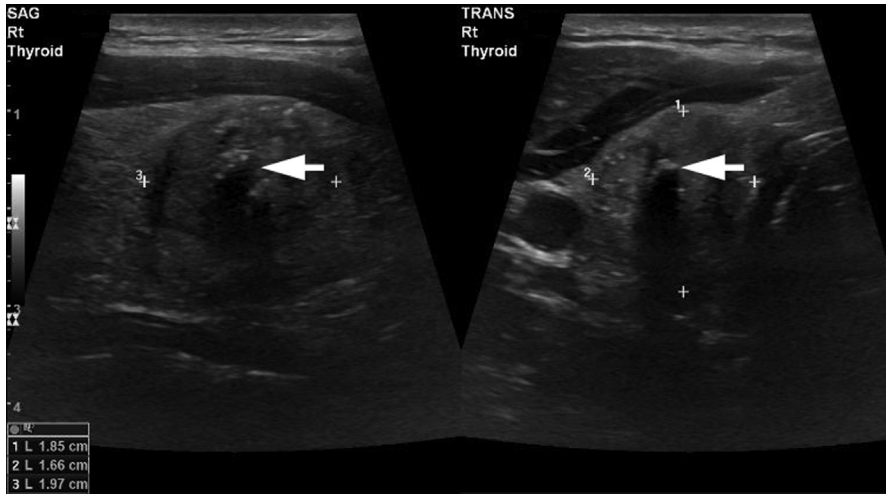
A 40-year-old man with biopsy-proven follicular variant papillary thyroid cancer. Transverse and longitudinal gray-scale ultrasound images show a hypoechoic nodule with ill-defined margins, PEF, and shadowing calcifications (*arrow*), and taller-than-wide shape, as measured by the calipers. Taller-than-wide shape is a highly specific indicator of malignancy.
